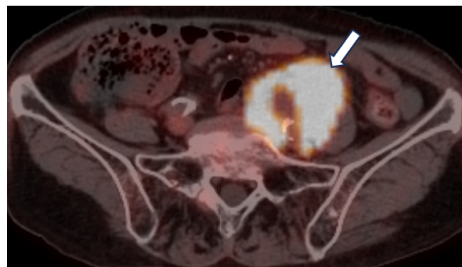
PET-CT image (coronal plane).
